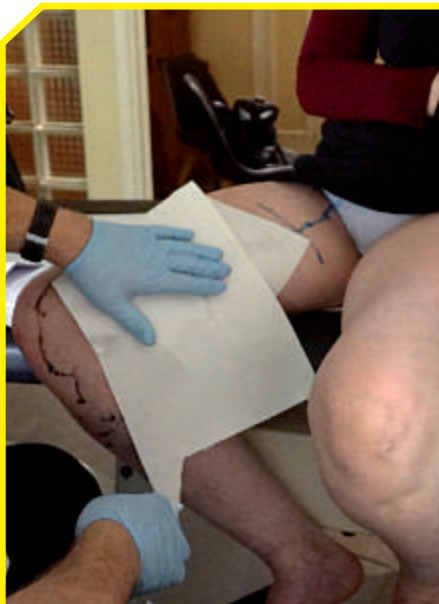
Wiping the ultrasound gel.
